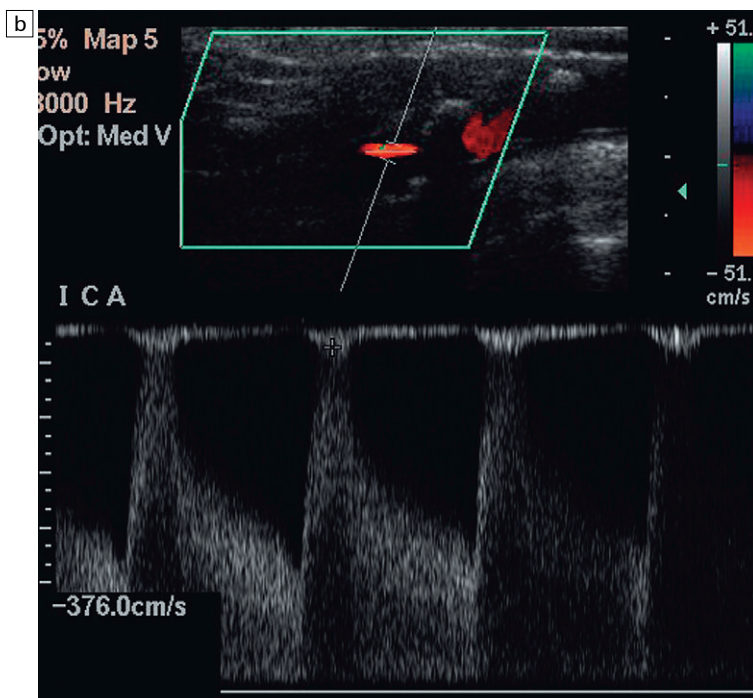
(a) The angle correction has been made aligning the cursor to the vessel wall resulting in a velocity estimate of approximately 2 m s^{-1} . (b) Using colour Doppler, the cursor is positioned along the line of the flow and results in a velocity of approximately 3.5 m s^{-1} .
